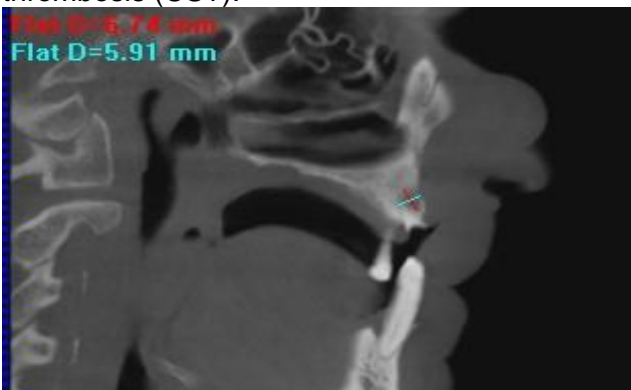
View of size of apical lesion in cone beam computed tomography
